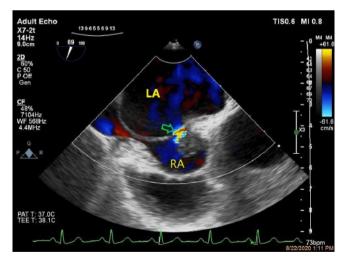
Transesophageal echocardiography shows a left-to-right shunt through a patent foramen ovale (arrow).
